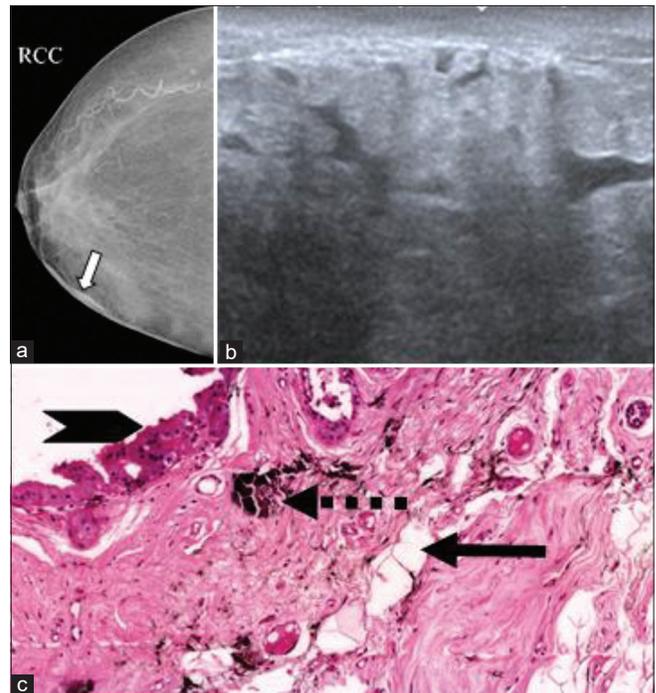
A 48-year-old female with bilateral non-cyclical mastalgia and a vague history of domestic accident 3 months back. Family history of breast cancer positive. (a) X-ray mammogram CC view of the right breast shows focal skin thickening (arrow) and benign vascular calcification in the outer quadrant. (b) Ultrasound image shows prominent ducts with surrounding edematous parenchyma, focal skin thickening, and no definitive mass. (c) H & E: Benign calcification (dotted arrow) with apocrine metaplasia (arrowhead) of ducts and adjacent fat necrosis (black arrow) $\times 200$
